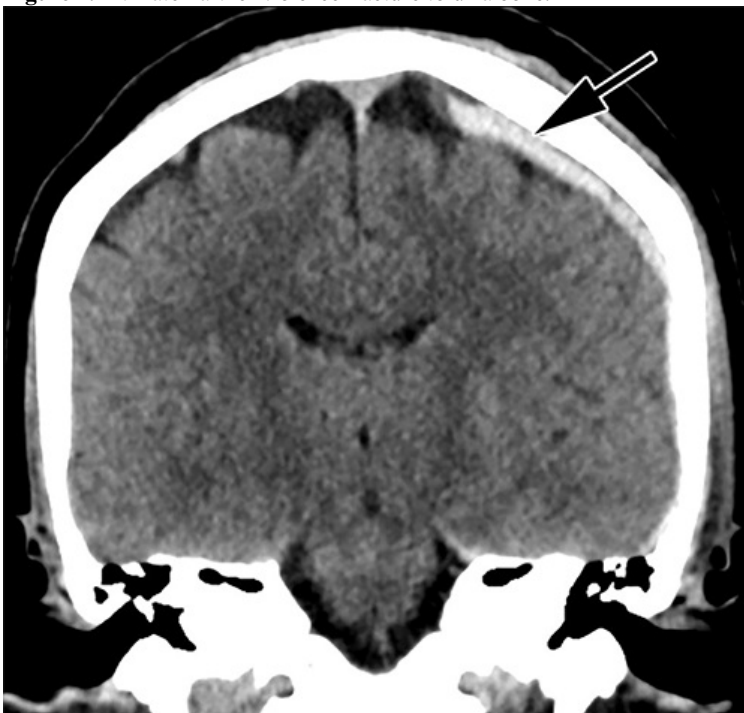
Head CT of intimate partner violence patient with left-sided parietal subdural hematoma (arrow).
